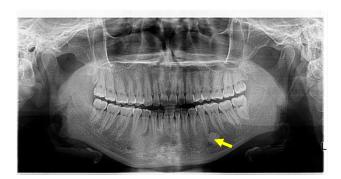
The dense bone island was found in one of the panoramic radiograph samples.
